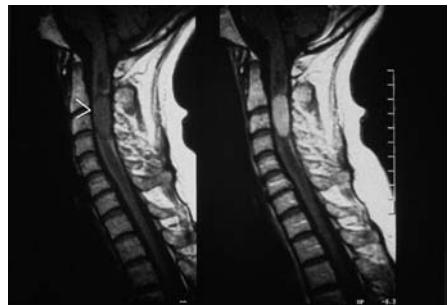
Sagittal MRI showing an ependymoma in the upper cervical spinal cord (left, arrow) with marked gadolinium-enhancement (right), delineated on both sides by a typical cyst.
